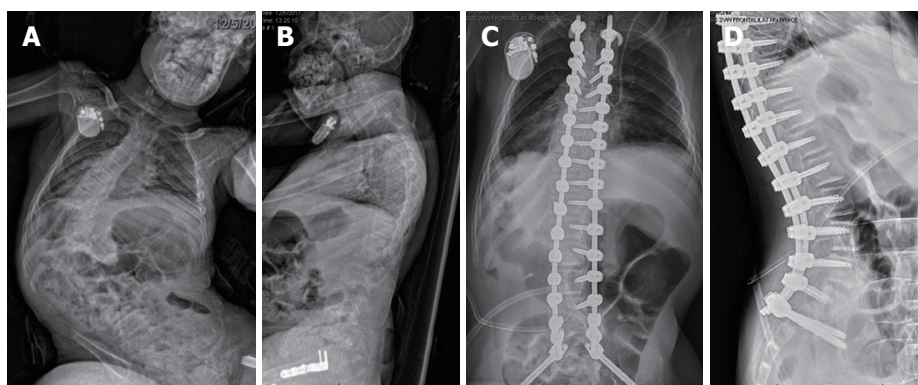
Pre-operative and post-operative radiographs in a patient with neuromuscular scoliosis who underwent T3 to pelvis instrumented posterior spinal fusion using navigation to place pedicle screw and S2-alar-iliac technique instrumentation. A: Posteroanterior; B: Lateral; C: Anteroposterior; D: Lateral.
